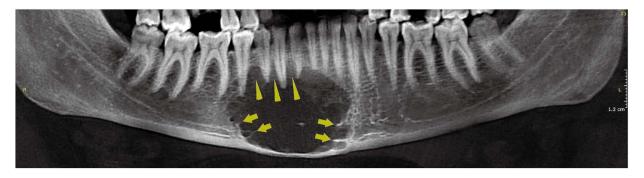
Glandular odontogenic cyst in the anterior aspect of the mandible. Panoramic reconstructed cone-beam computed tomographic image with 2-mm thickness shows scalloped borders (arrows) and scalloping between roots (arrowheads).
